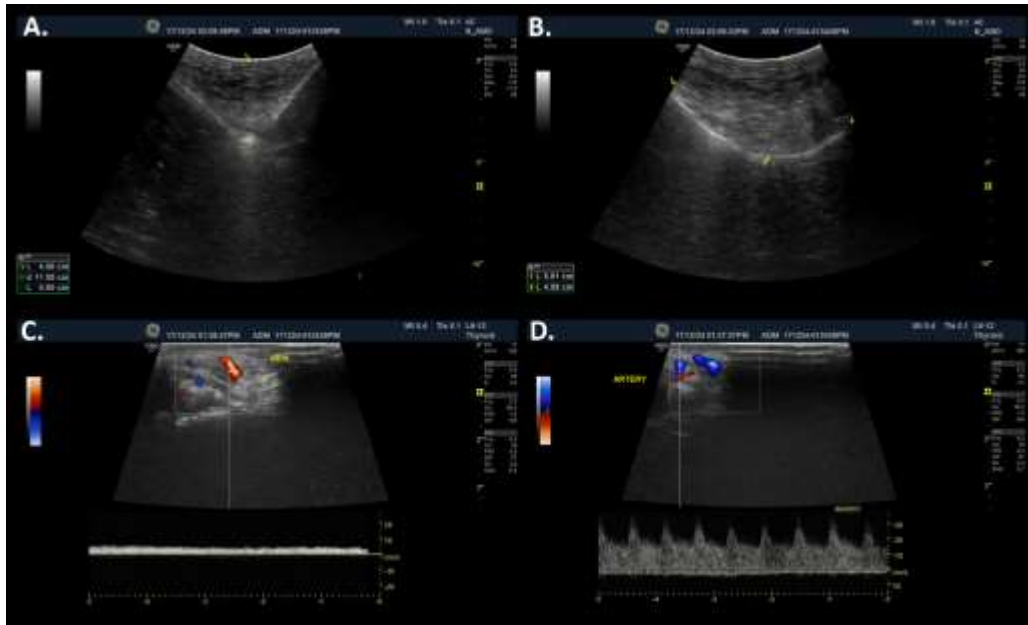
Ultrasound images showing a well-defined, heterogenous mass (A., B.). On Colour Doppler images, the stalk shows good arterial (D.) and venous flow (C.)
